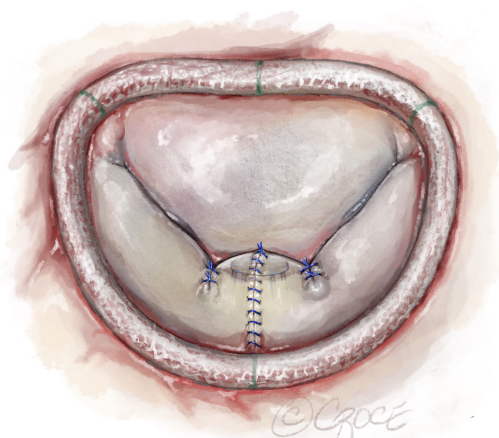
Final saline testing confirms valve competence. In Barlow's disease, small leaflet edge irregularities may create minor coaptation jets; marking them with blue ink aids identification after drainage. Over 90% close with a simple 5-0 suture, and added stitches smooth the coaptation zone. The repair should be symmetrical—any asymmetry may indicate subtle prolapse or restriction, often clarified by reviewing pre-repair TEE. Minor defects are corrected with commissuroplasty or free-edge remodeling. A complete remodeling ring standardizes anterior–posterior closure and ensures long-term durability and compatibility with future valve-in-ring therapy. TEE, transesophageal echocardiography.
